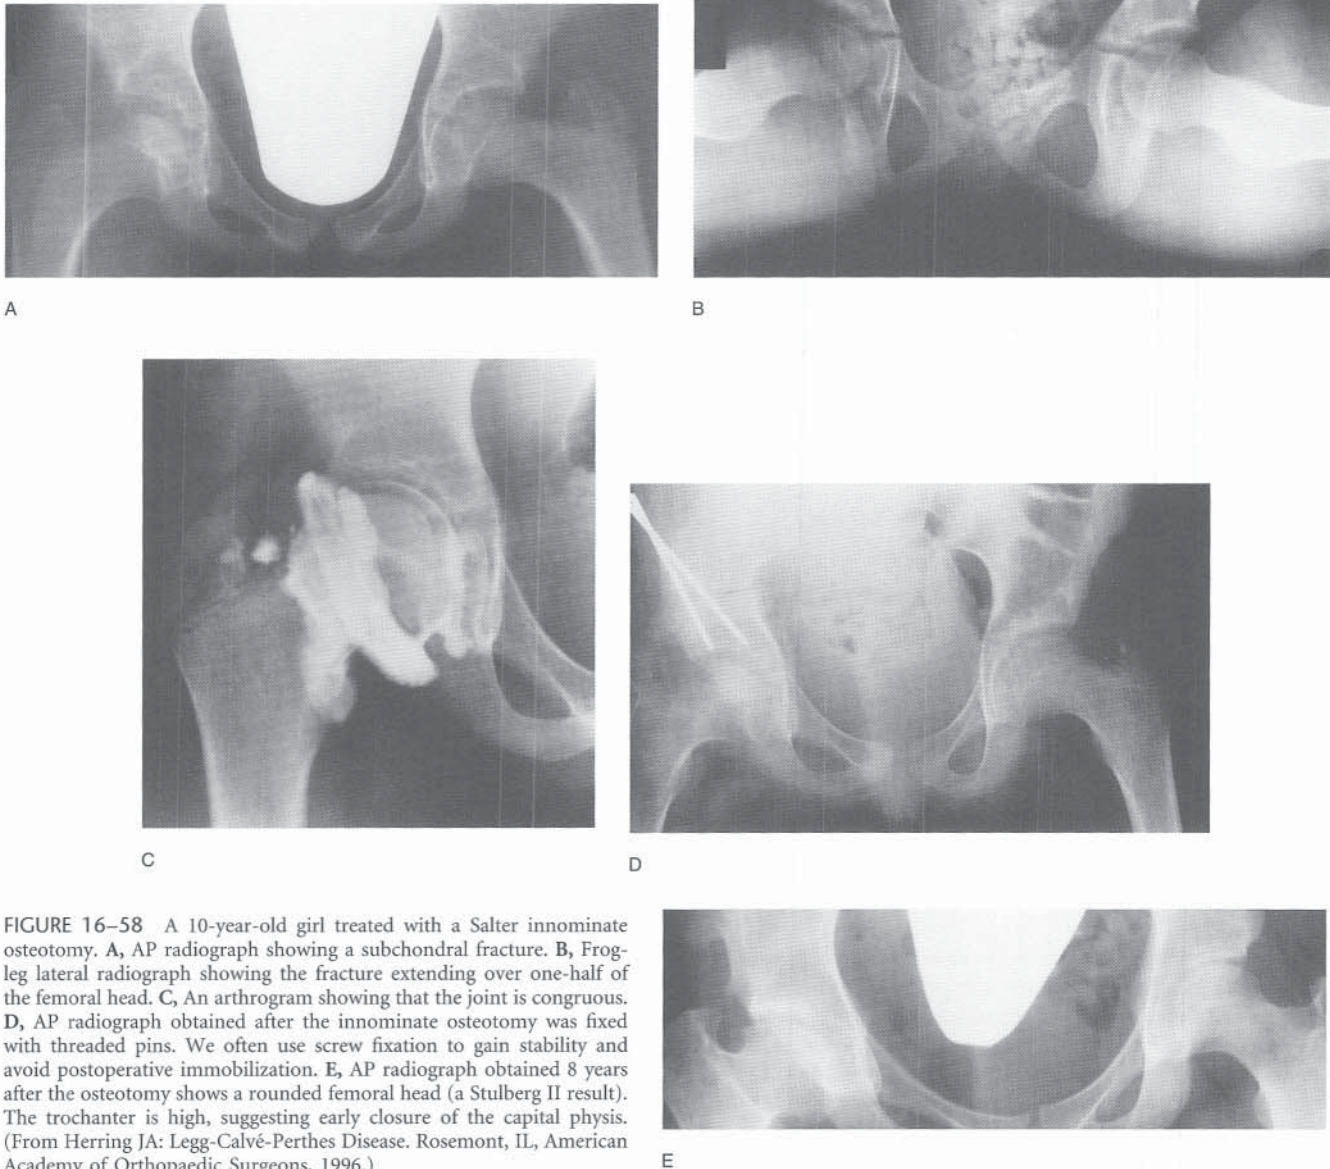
A 10-year-old girl treated with a Salter innominate osteotomy. A, AP radiograph showing a subchondral fracture. B, Frog-leg lateral radiograph showing the fracture extending over one-half of the femoral head. C, An arthrogram showing that the joint is congruous. D, AP radiograph obtained after the innominate osteotomy was fixed with threaded pins. We often use screw fixation to gain stability and avoid postoperative immobilization. E, AP radiograph obtained 8 years after the osteotomy shows a rounded femoral head (a Stulberg II result). The trochanter is high, suggesting early closure of the capital physis. (From Herring JA: Legg-Calvé-Perthes Disease. Rosemont, IL, American Academy of Orthopaedic Surgeons, 1996.)
